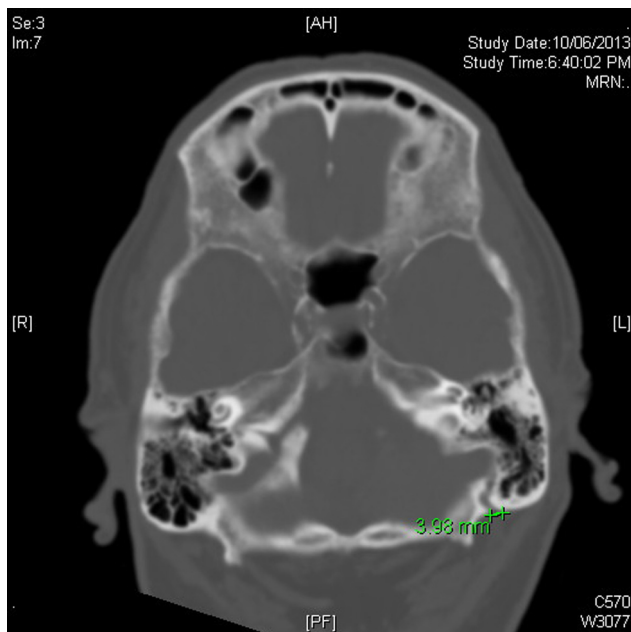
CT showing tortuous mastoid canal with external foramen measuring 3.98 mm.
